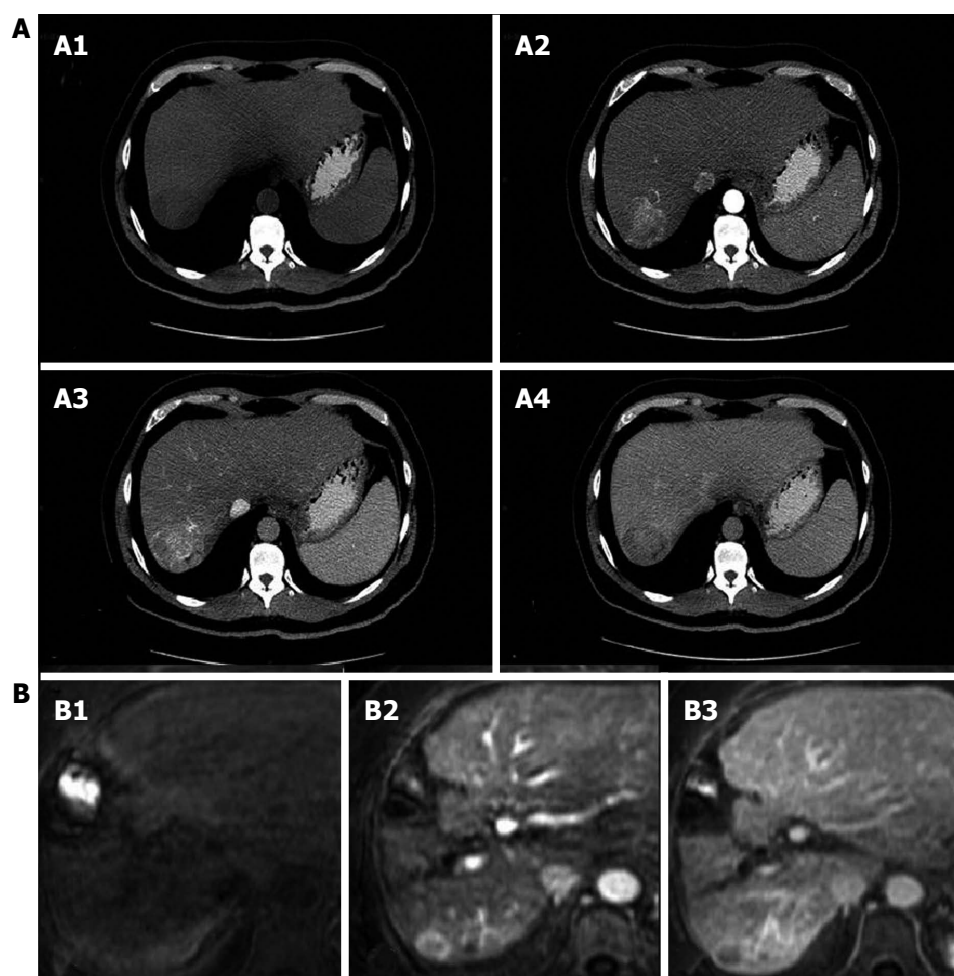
Contrast - enhanced computed tomography and Dynamic contrast-enhanced magnetic resonance imaging. A: Classical imaging pattern of hepatocellular carcinoma in contrast-enhanced computed tomography; A1: Simple phase, hypodense lesion in segment VII; A2: Arterial phase; A3: Enhanced portal; A4: 3 min late-phase washout; B: Diagnostic dynamic-contrast magnetic resonance imaging with classical pattern; B1: Simple phase; B2: Portal phase; B3: late-phase washout.
